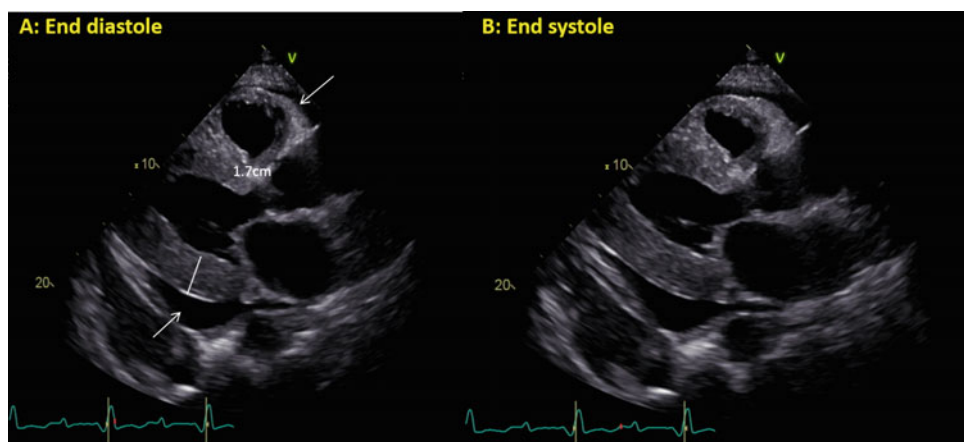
2D transthoracic echocardiogram. Parasternal long-axis view at a end diastole and b end systole showing severe concentric left ventricular hypertrophy, increased ventricular mass, and a free-flowing
